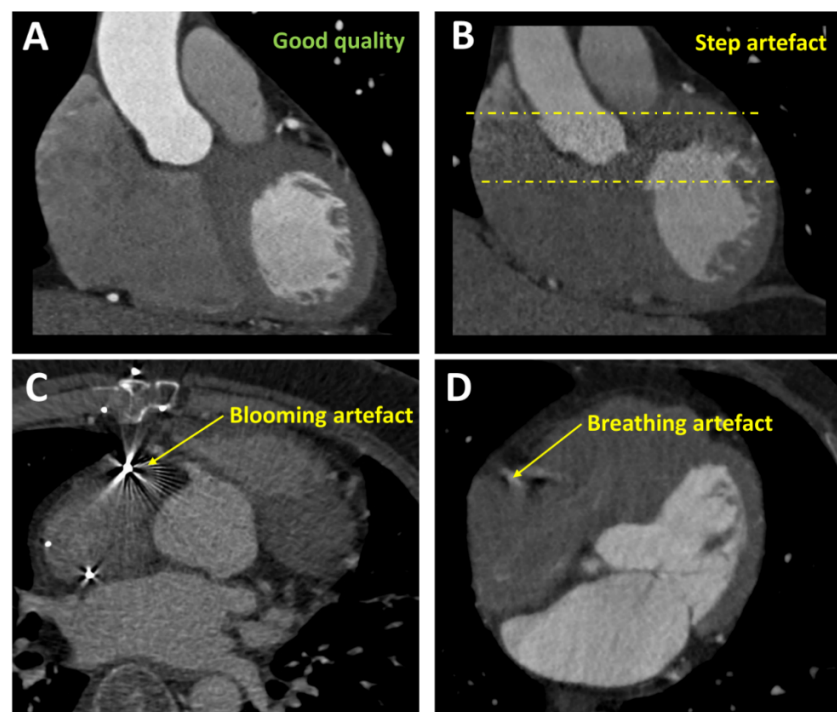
Quality control and common image artefacts. (A) A coronal view of a good quality coronary computed tomography angiogram (CCTA). (B) A stair-step artefact due to the use of a CT scanner that obtains the whole image in three different subset before stitching them together. (C) Blooming artefact due to a pacemaker lead that obscures the right coronary artery. (D) Breathing/motion artefact which results in blurring of the right coronary artery contour.
